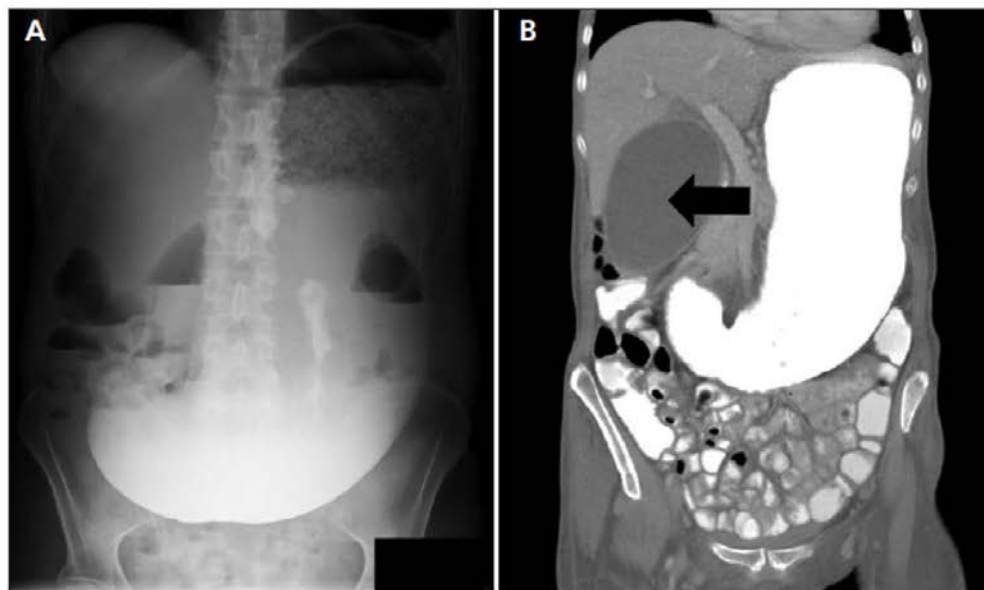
Abdominal radiograph (A) following ingestion of water-soluble contrast media (100 mL), showing pooling in the pelvic region of a 60-year-old woman with poorly controlled diabetes and severe diabetic gastroparesis. The computed tomograph (B) was obtained shortly after ingestion of the contrast media and shows dilatation of the stomach and gallbladder (arrow).
